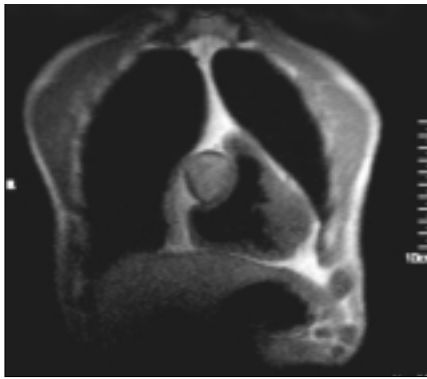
Coronal T2-weighted image of the thorax demonstrates the large spherical mass
